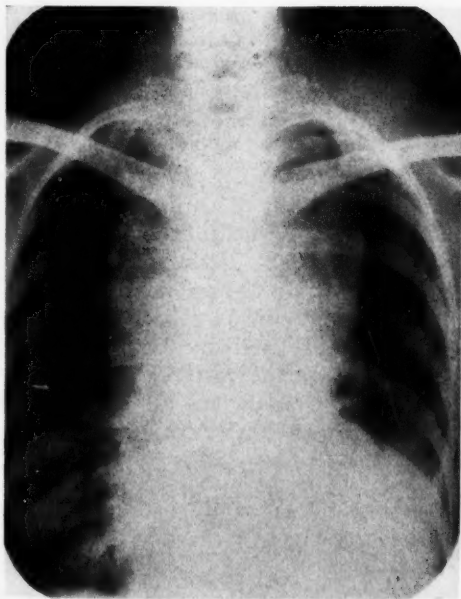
X-ray of chest showing thyroid tumor.
